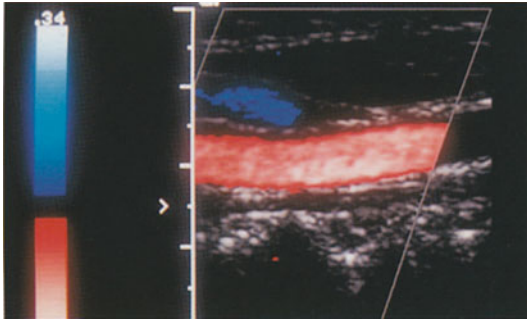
Characteristic CCDS image obtained with a linear transducer: since there is a constant angle between the Doppler beam and the column of flowing blood, the entire vessel lumen is recorded in the same color (red in this case). Note the white parallelogram indicating an offset angle for the Doppler beam and defining the area of interest to be displayed in color
